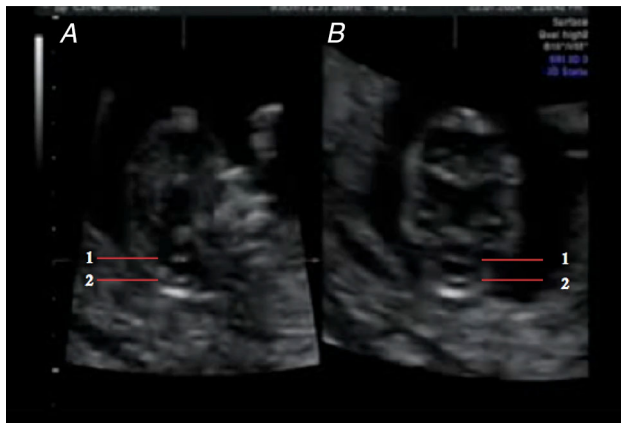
3D ultrasound image showing *A* (sagittal) and *B* (axial oblique) plane. *Line 1* represents the posterior border of brainstem. *Line 2* represents the choroid plexus of fourth ventricle
